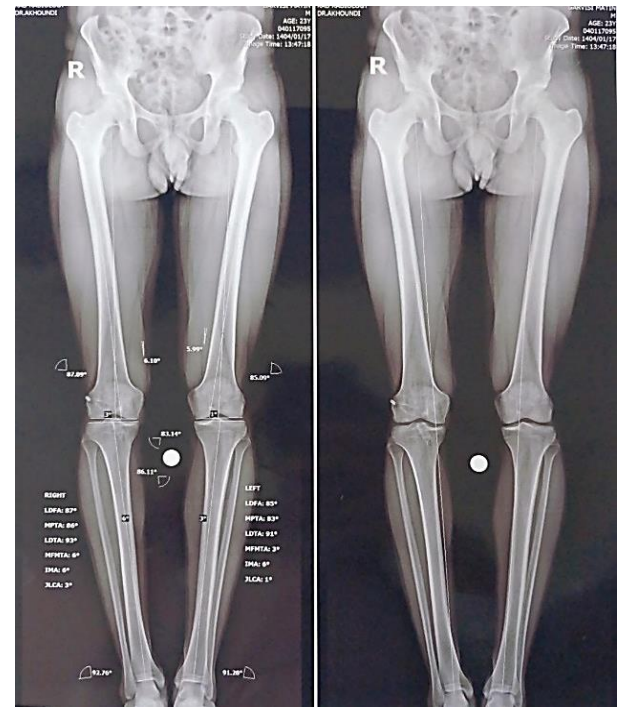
Preoperative radiographic evaluation of lower limb alignment. Standing long-leg radiographs demonstrating the measured alignment parameters: lateral distal femoral angle (LDFA) 87°, medial proximal tibial angle (MPTA) 86°, joint line convergence angle (JLCA) 3°, mechanical femoral-tibial angle (MFMTA) 6°, and intermetatarsal angle (IMA) 6° of varus
